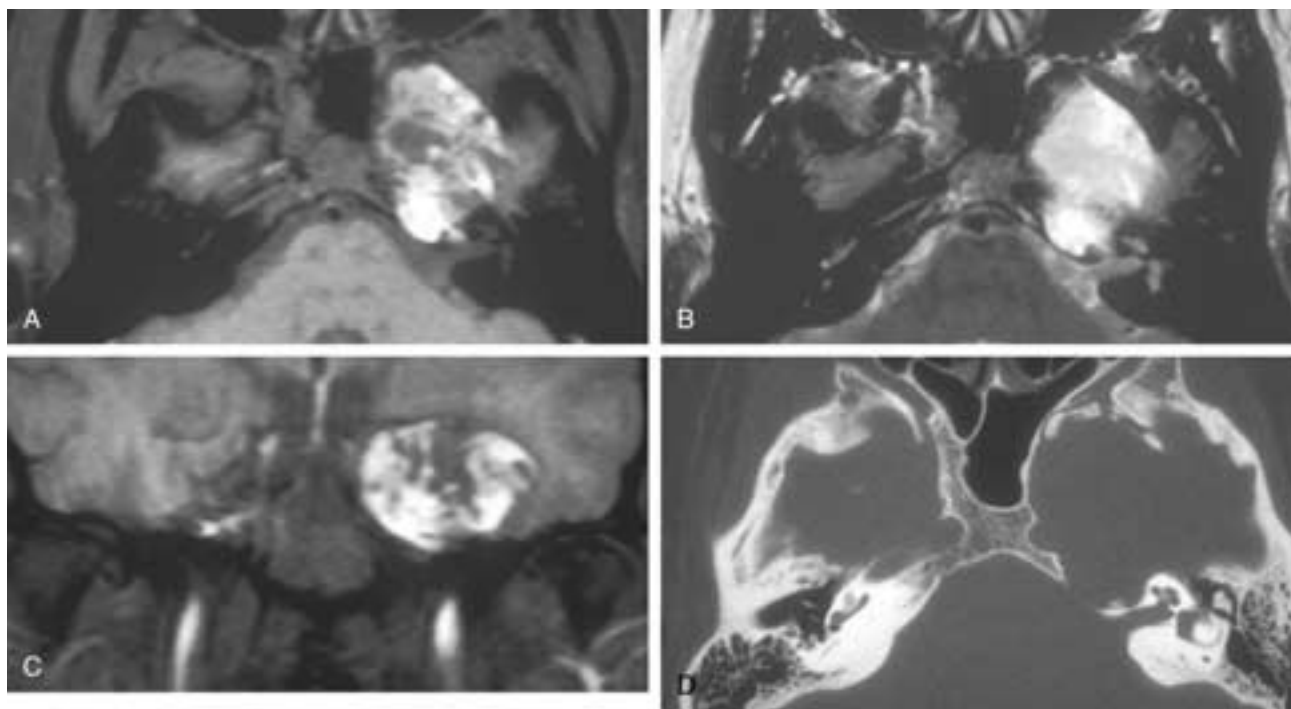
Skull base epidermoid. A to C, T1-weighted, T2-weighted, and T1-weighted coronal postgadolinium images, respectively. Extensive epidermoid tumor invading the skull base shows heterogeneous high signal intensity on both T1- and T2-weighted images without enhancement. D, Bone algorithm CT scan. Note the sharp margin of the lesion.
